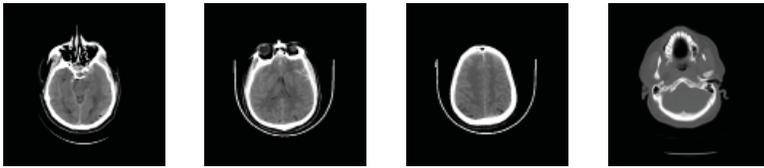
The initial CT brain of the patient showing (a) a small Lt occipital acute EDH with a small hypodense spot ?? swirl sign. (b) SAH Fisher grade II in the Lt Sylvian and interhemispheric with bifrontal hypodensity suggesting brain contusions and small size lateral ventricles. (c) interhemispheric SAH and loss of the frontal cortical sulci bilaterally from the brain oedema. (d) Lt occipital linear fissure fracture behind the mastoid bone with no blood inside the mastoid air sinus
